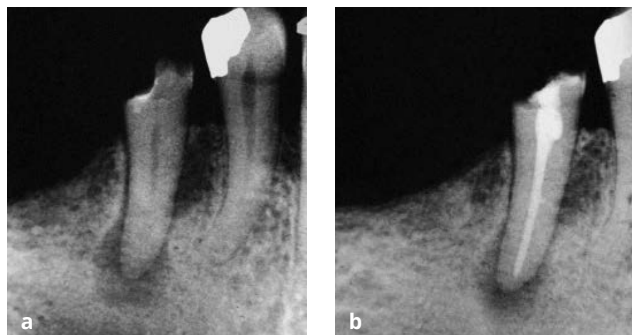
Periapical radiograph of left maxillary premolar region reveals the presence of severe periodontal lesions in this area with generalized vertical and horizontal bone loss along the root surfaces.
